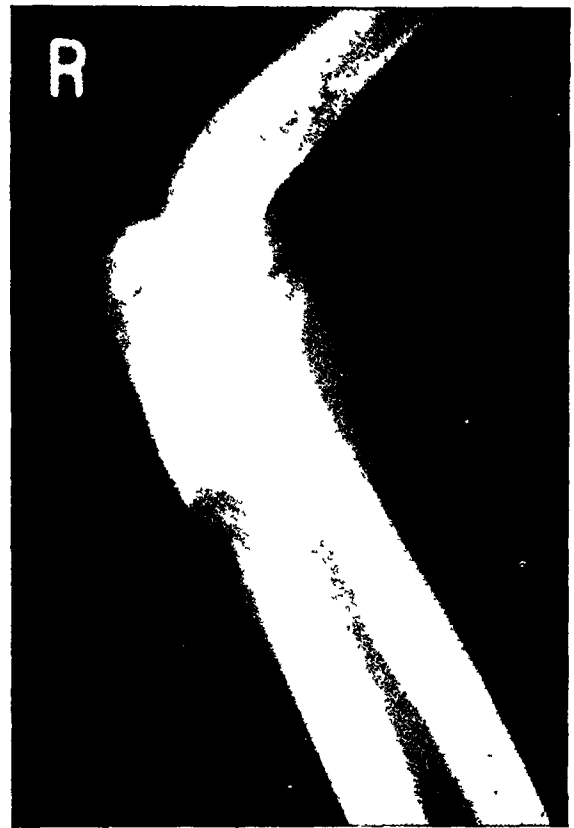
Check roentgenogram taken August 19. There is almost complete local dissolution of the ulnar shaft.
